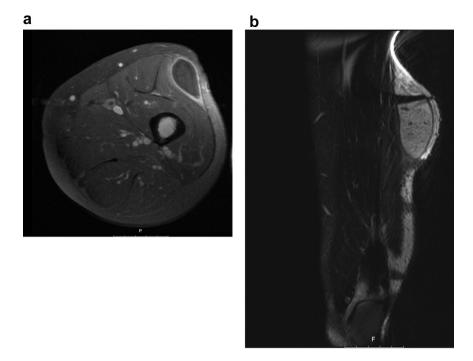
MRI scan (a) of the left thigh axial T1 post gadolinium. (b) MRI left thigh coronal T2 fat-saturated scan. MRI, magnetic resonance imaging.
